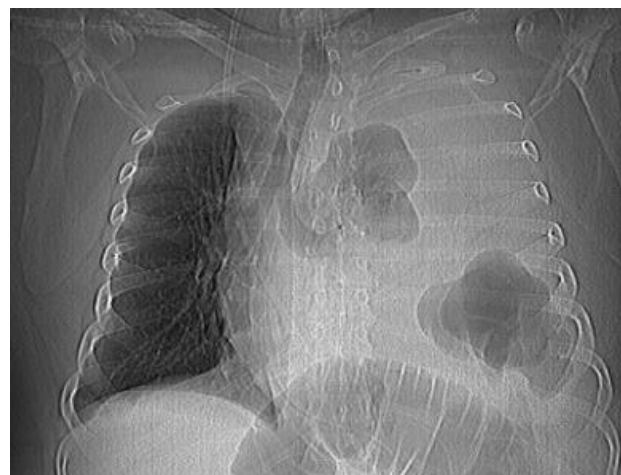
Chest x-ray: deviation of the trachea is evident, left lung cannot be visualized, presence of colon in the right hemithorax.
